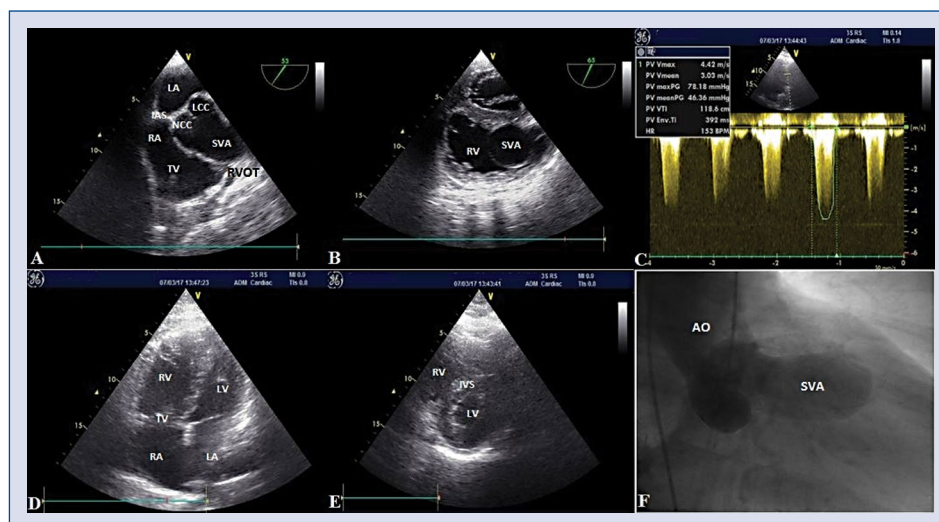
Transoesophageal echocardiography demonstrating a large right sinus of Valsalva aneurysm (SVA) protruding into the right ventricular outflow tract (RVOT) in the short axis view (A, B), transthoracic echocardiography showing RVOT obstruction in the parasternal short axis view on continuous wave Doppler (C), transthoracic echocardiography showing dilated right ventricle (RV) and right atrium (RA) in the apical-4-chamber view (D) and D-shaped left ventricle (LV) in the parasternal short axis view (E), aortography demonstrating a giant right SVA (F); AO — aorta; IAS — interatrial septum; IVS — interventricular septum; LA — left atrium; NCC — non-coroner cusp; LCC — left-coroner cusp; TV — tricuspid valve.
